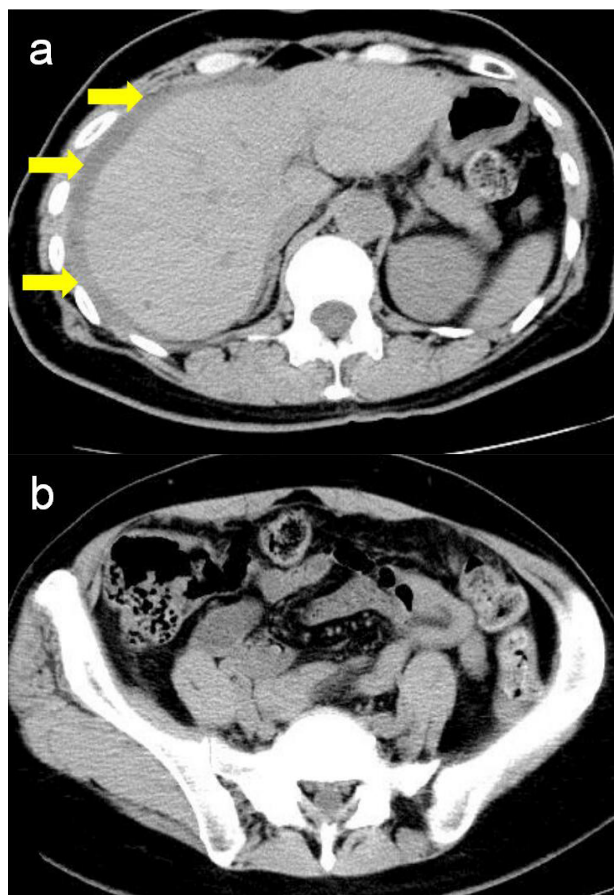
Abdominal computed tomography (CT) scan showed ascites around a liver (yellow arrows) (a) but no ascites in the pelvic cavity (b) at admission.
